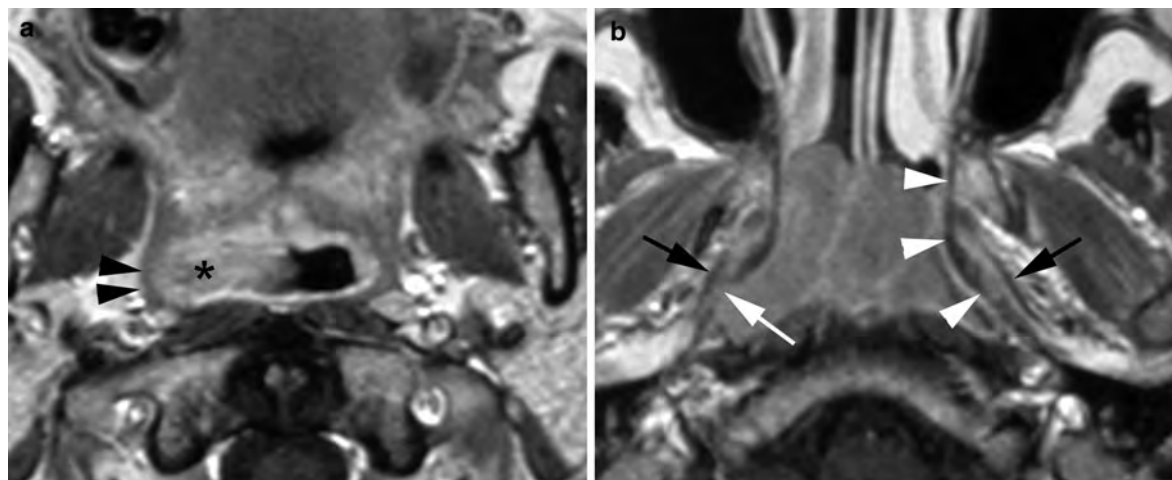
Axial gadolinium-enhanced T1-weighted spin echo images, showing the relationship between the superior constrictor muscle, the pharyngobasilar fascia and a nasopharyngeal cancer. a Axial section at level of soft palate. The superior constrictor muscle (arrowheads) is surrounding the nasopharynx; the tumor (asterisk) is confined to the nasopharyngeal
